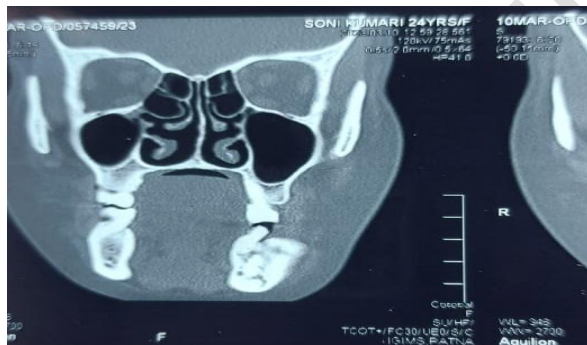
The coronal and sagittal sections of contrast-enhance computed tomography
